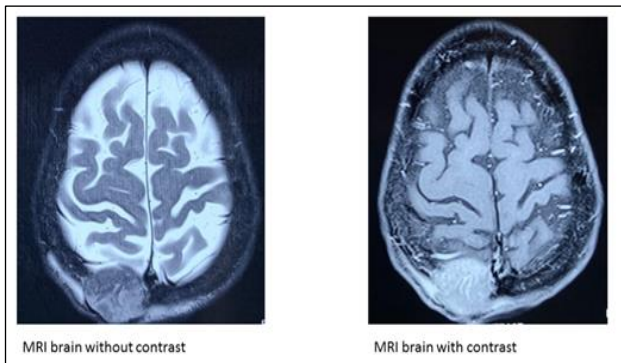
MRI scan of the brain solitary osteolytic lesion with exo and intracranial extradural soft tissue in parasagittal right high parietal bone with defect measuring 3.8 cm (Left panel) with post-contrast hyper-enhancement (Right panel).
